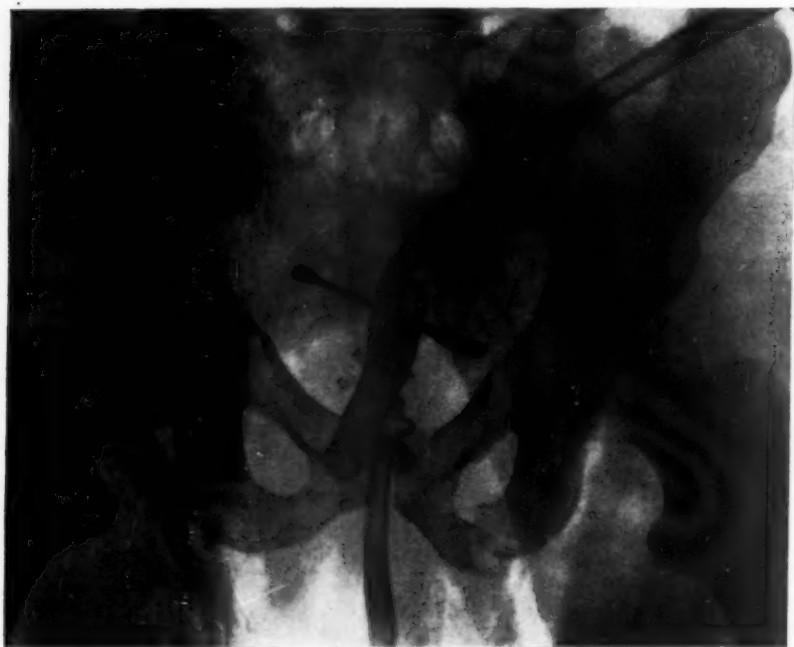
Radiograph through plaster cast showing fractures of superior and inferior rami of right and left pubis. The de Pezzer catheter in the urethra with its cuff at the internal meatus together with the suprapubic cystostomy catheter and the prevesical drainage tube are also shown.
